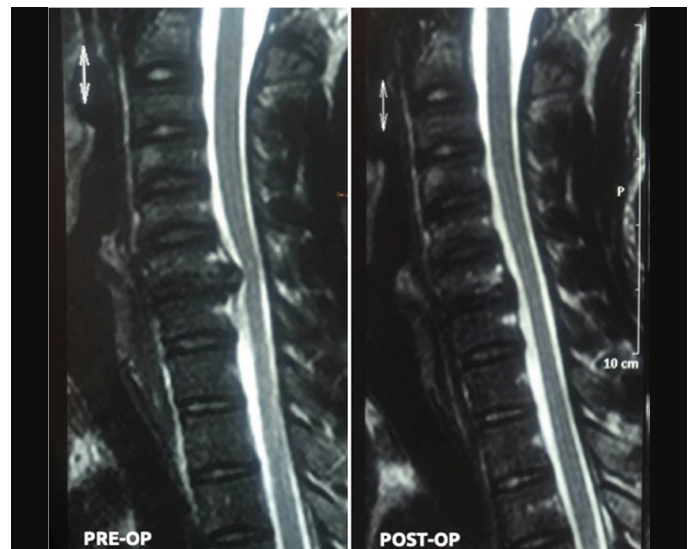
Pre and Postoperative MRI.
